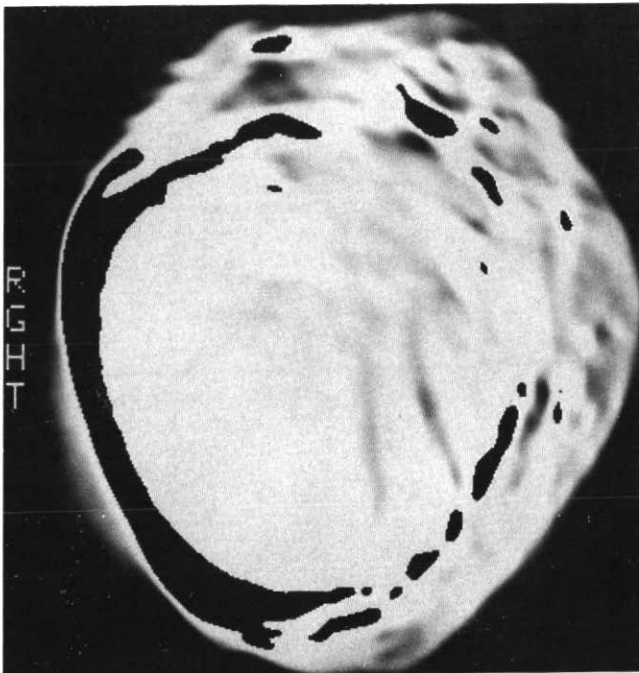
CT image of *Diplodocus* caudal vertebrae. The ossification, though circumferential, is demonstrated to be physically separate from the vertebral body. Black spaces identify the separation.
